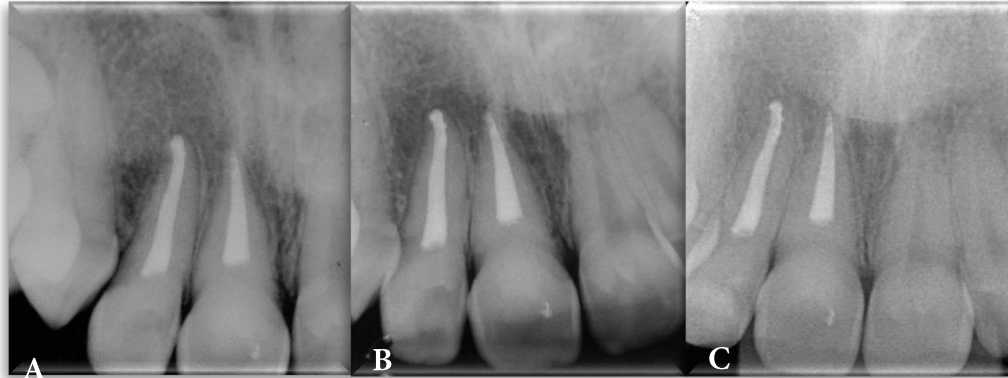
Endodontic fill. A) X-ray at 12/2008; B) Control X-ray at 09/2013; C) Control X-ray at 06/03/2018
